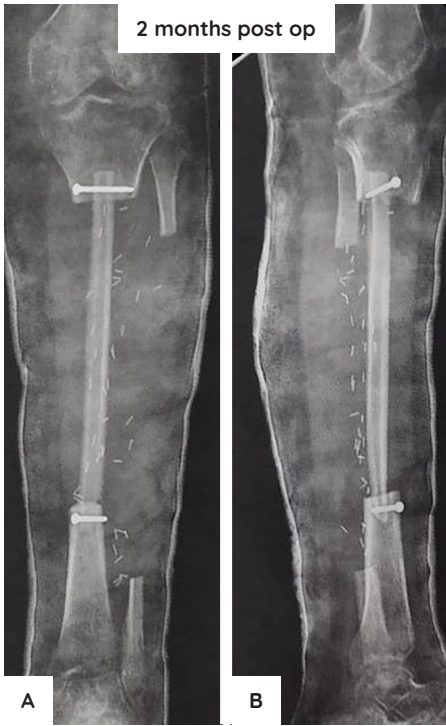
AP (A) and lateral (B) radiographs at two months post op showing hypertrophy of the fibular graft.
